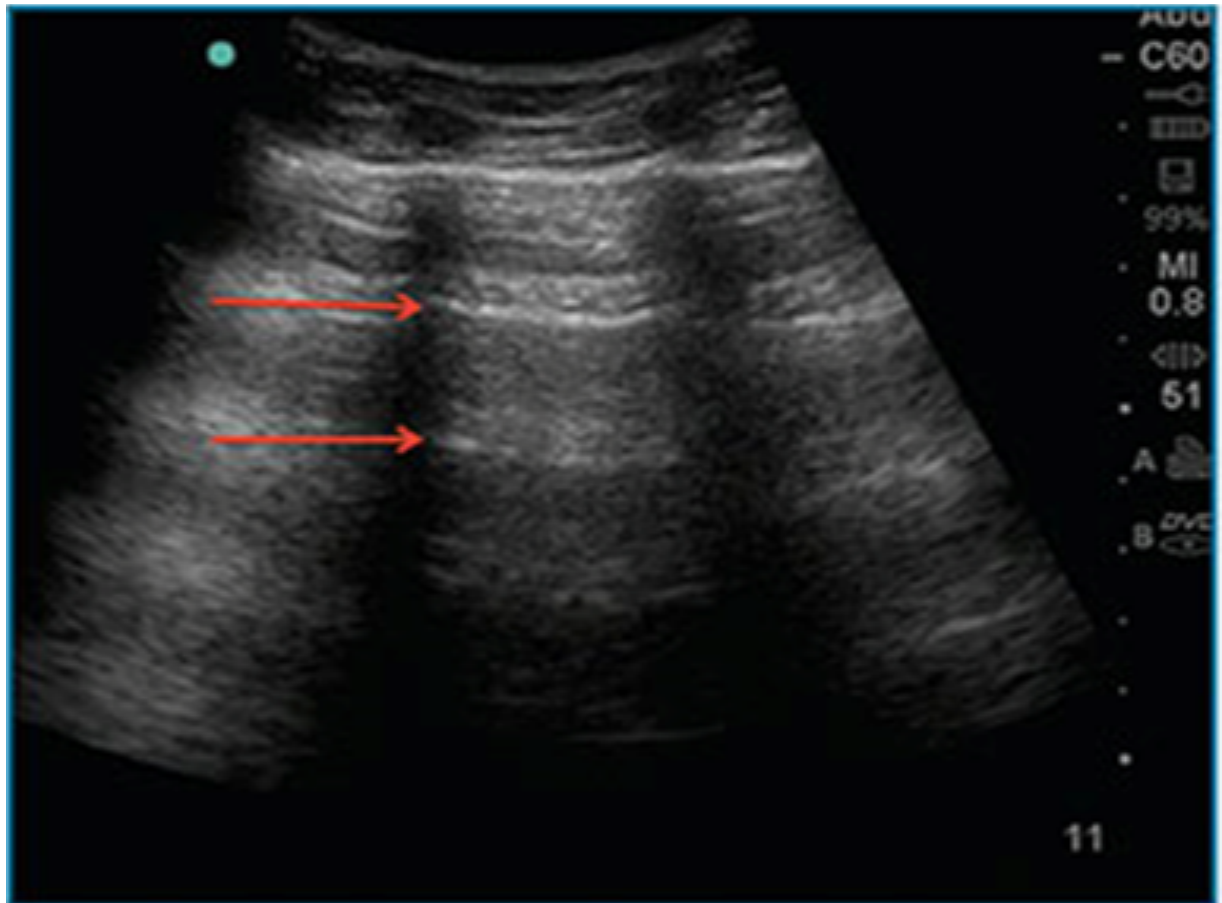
Ultrasound demonstrating A-lines artifacts (red arrows), a repetitive reverberation artifact of pleura.
